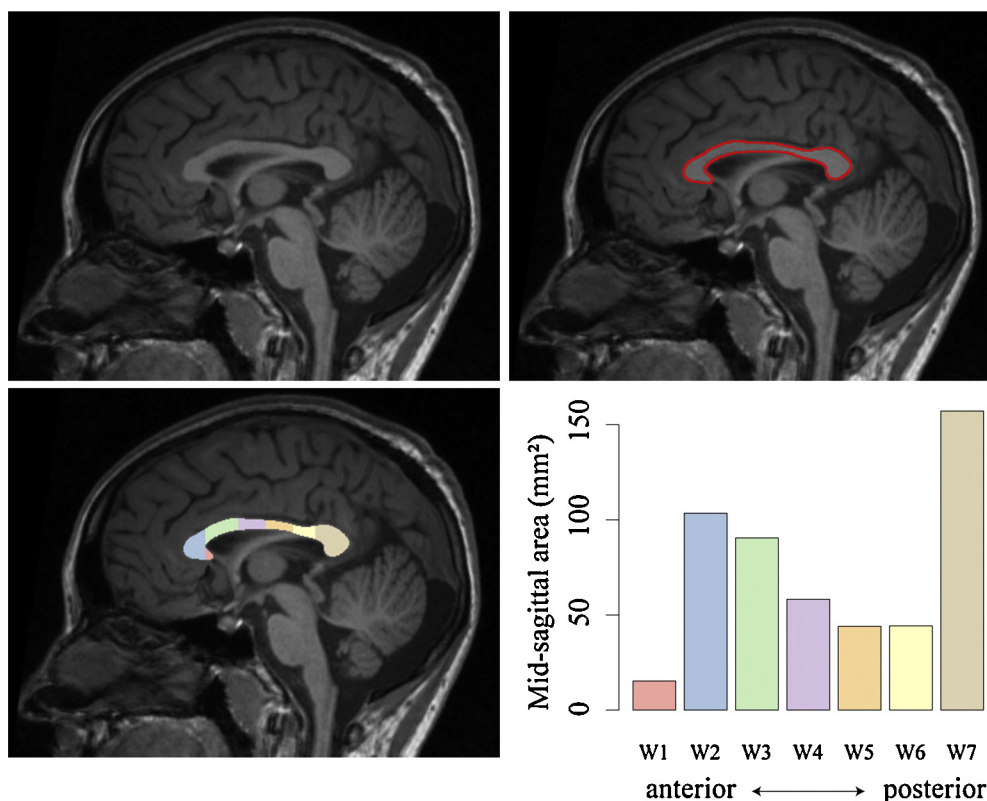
Corpus callosum segmentation using T1-weighted MRI. The mid-sagittal plane is identified (A), corpus callosum is segmented (B) and subdivided according to the Witelson scheme (C). The cross-sectional area of each Witelson subregion is shown in D. Total cross-sectional area for this individual is 513 mm².
